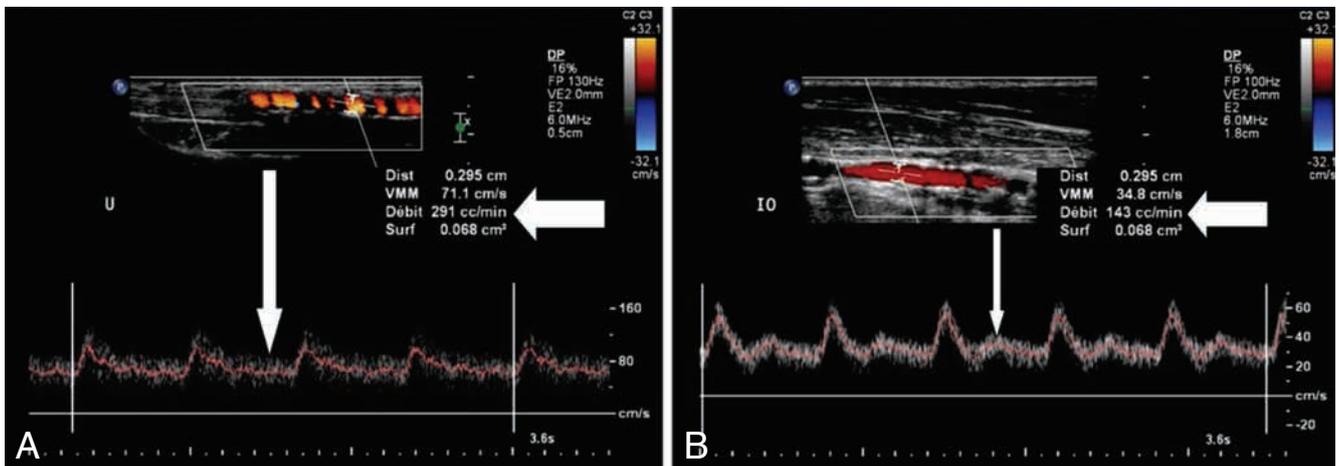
Ulnar (A) and interosseous (B) triplex: the enhanced flows (thick arrows) and the low resistive Doppler waves (thin arrows).
